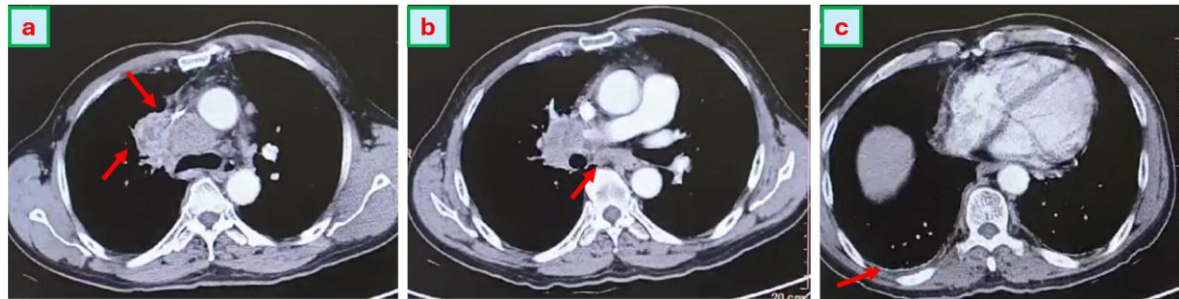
Thoracic CT scan with Contrast at First Hospitalization
